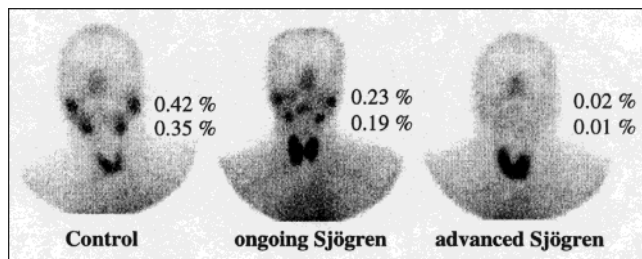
Quantitative salivary gland scintigraphy of a healthy control, of patients with beginning and severe Sjögren's syndrome. Numbers on scintigrams represent $^{99\text{m}}\text{Tc}$ -pertechnetate uptake in percentage of the activity in submandibular and parotid glands, respectively. Note the parenchymal impairment of all salivary glands in beginning and advanced Sjögren's syndrome.
